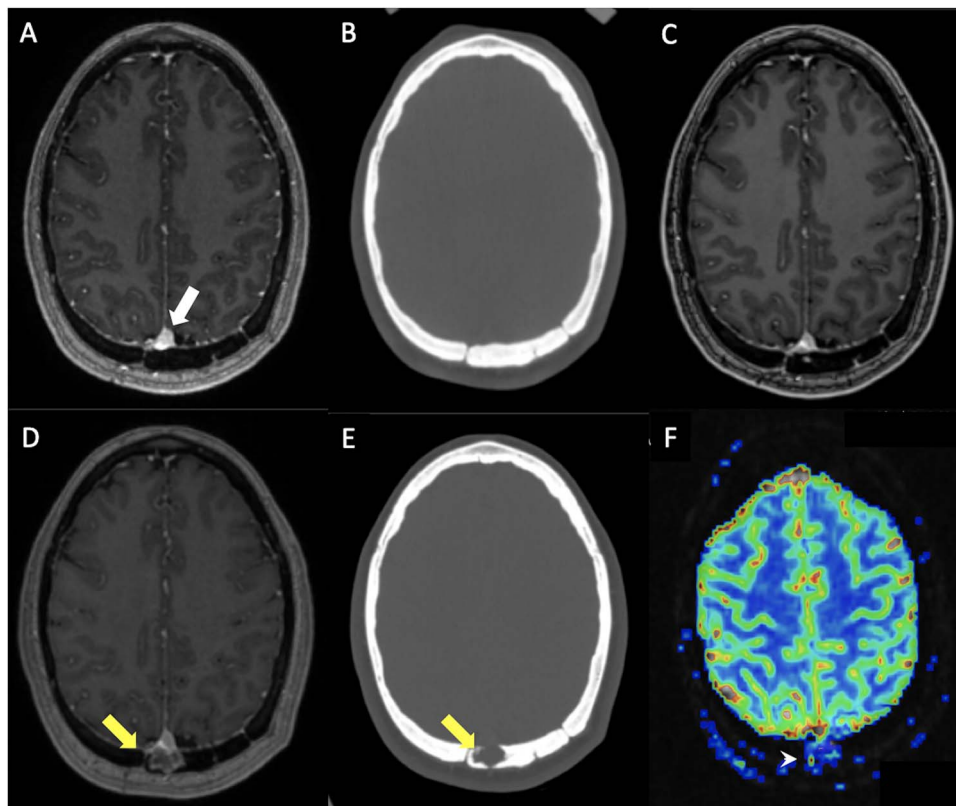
Case 1 prior to and at initial presentation of osteolytic lesion; (A) T1 post-contrast MRI axial slice obtained at the time of SRS showing the initial meningeoma recurrence (white arrow) and (B) comparable axial CT slice also obtained at the time of SRS; (C) T1 post-contrast MRI 4 years post-SRS and (D) at the development of the lytic bone lesion 5 years post-SRS (denoted by yellow arrow); (E) CT at the time of development of the lytic bone lesion 5 years post-SRS (denoted by yellow arrow); (F) corresponding relative cerebral blood volume map (from dynamic susceptibility contrast perfusion imaging) reveals relative hypoperfusion of the enhancing lesion (denoted by white arrowhead; red = increased perfusion, blue = decreased perfusion).
